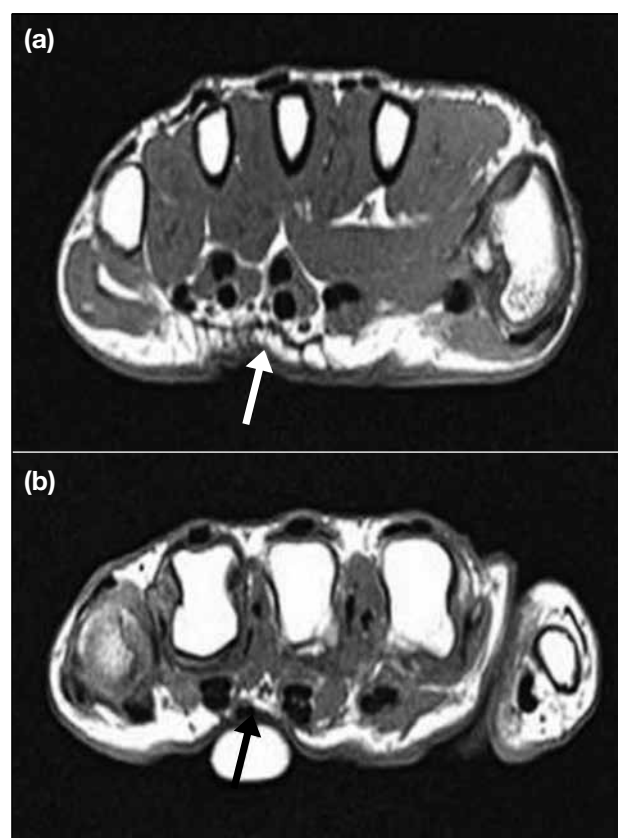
Dupuytren's contracture in a 62-year-old woman who presented with left palm mass for 3 years: (a) T1-weighted axial magnetic resonance image showing thickened palmar aponeurosis with hypointense signal (white arrow). (b) T1-weighted axial magnetic resonance image at a more distal level as shown in (a) demonstrates a hypointense plaque-like lesion at the subcutaneous tissue (black arrow), attaching to the palmar aponeurosis.
